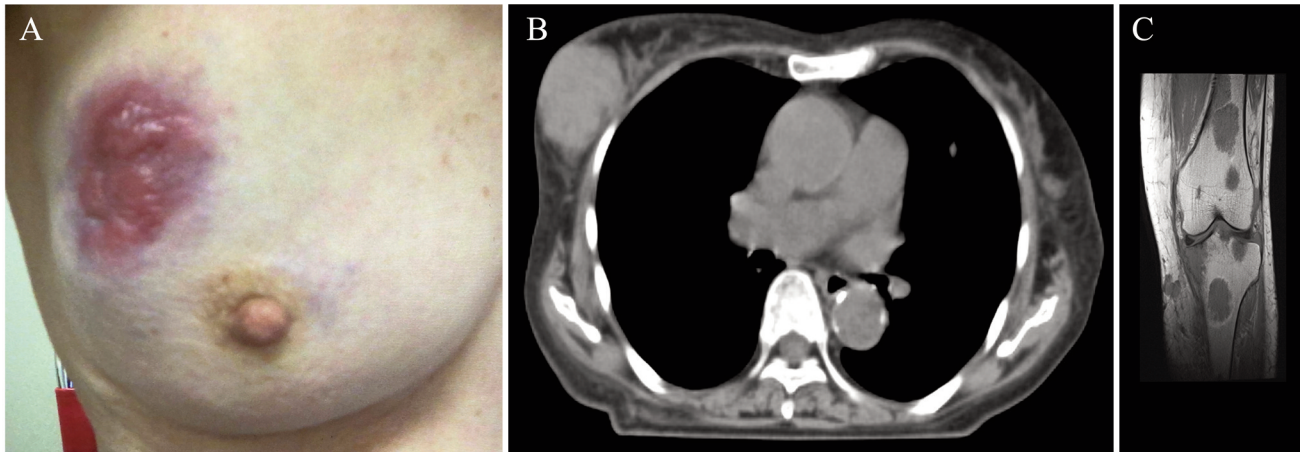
Pretreatment appearance (A) and computed tomography (B) images of the right breast. (C) Pretreatment magnetic resonance imaging of the left leg.
